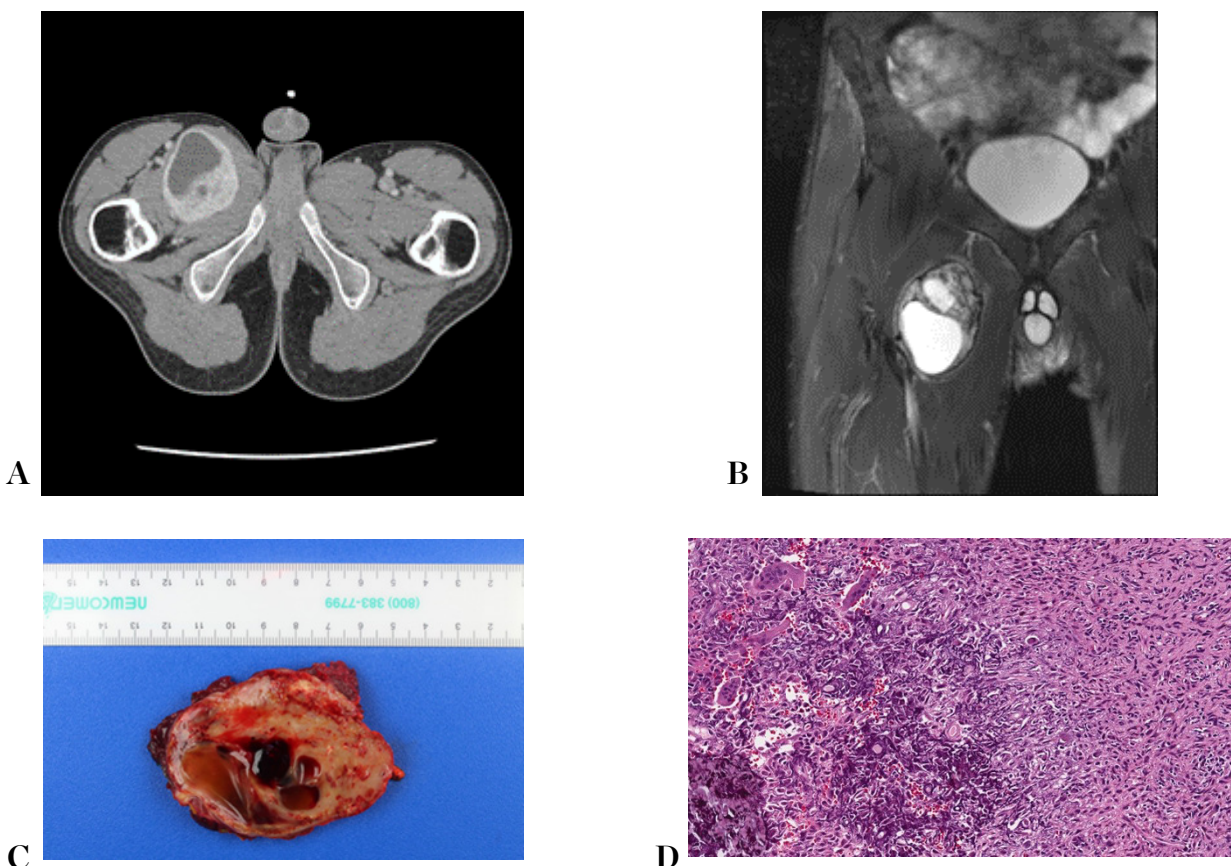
A) Contrasted CT scan of the pelvis showing a 5.5 x 7.4 cm mass anteriorly centered at right adductor brevis muscle. B) T2 fat suppressed MR image of pelvis/thigh. C) Gross photograph of phosphaturic mesenchymal tumor showing mass with cystic change and hemorrhage. D) Tumor consists of spindled cells with areas of calcification. Osteoclast-like giant cells are also present.
